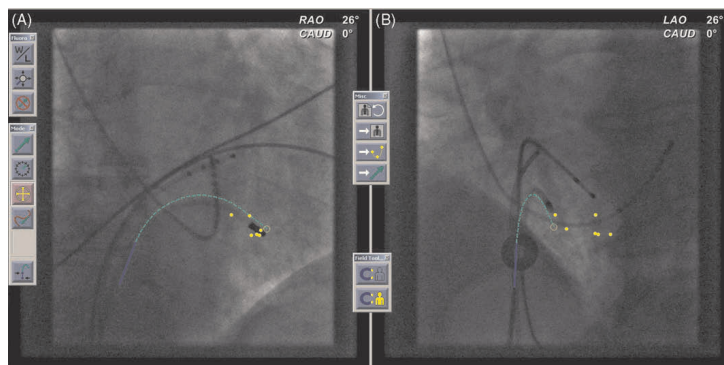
Part of the working screen of the Navigant workstation. The two radiographic views, with the His bundle, coronary sinus, and right ventricular catheters, are used with target-based navigation to indicate where the catheter should be placed. Previous positions are indicated by the closed yellow dots. The predicted catheter position, as shown in green, (with catheter shaft and pivot point in blue) is slightly different from where the catheter has finished and this sometimes requires some correction. The screen includes some of the tools used for different navigation modes.
